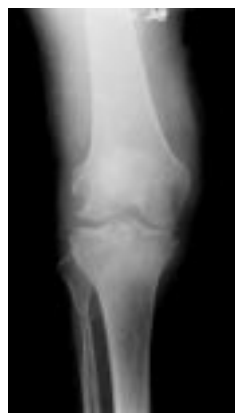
Right knee radiograph.
